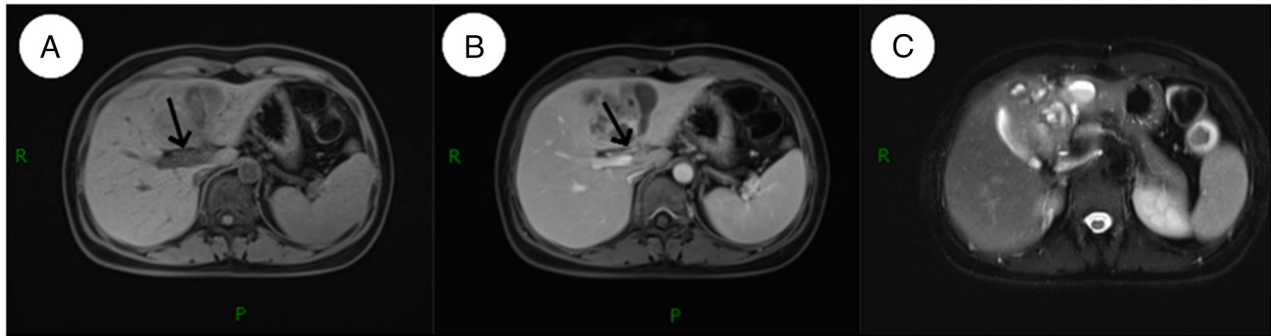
Preoperative abdominal magnetic resonance imaging examination results. (A) T1WI results showing the tunnel sign (arrow). (B) Gadolinium-enhanced T1WI results showing tunnel wall enhancement, with no enhancement in the tunnel itself (arrow). (C) T2WI results exhibiting high signal intensity and mildly dilated terminal bile ducts can be seen both in the center and periphery of the lesion. WI, weighted imaging; P, CT section was started from the posterior side; R, CT section was started from the right side.
